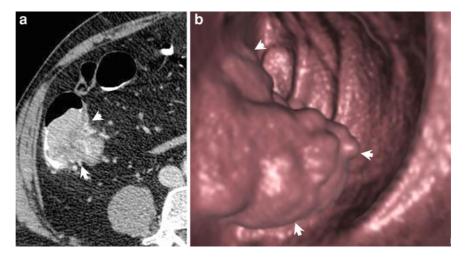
Contrast-enhanced CT Colonography with fecal tagging. Axial scan in supine decubitus (a) and endoluminal view in prone (b). Vegetating cancer (5 cm in largest diameter) located in the cecum with involvement of the ileo-cecal valve and adjacent peri-colonic tissue (arrow heads)
